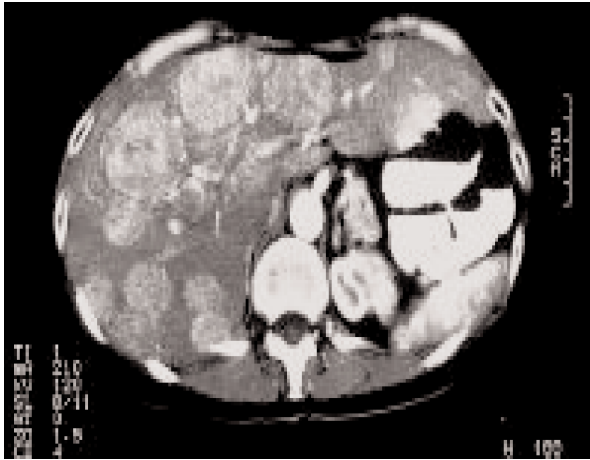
Liver, metastases. Characteristic appearance of carcinoid liver metastases on contrast-enhanced axial CT scan through the upper abdomen, which shows early arterial enhancement of the liver metastases.
